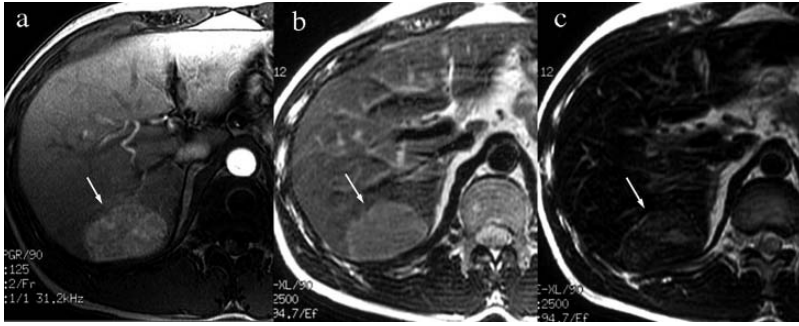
Focal nodular hyperplasia in a 34-year-old male. In the arterial phase of dynamic MR imaging, a well-enhanced tumor is noted in S7 (a, arrow). Pre-contrast T_2W -FSE reveals a high-intensity mass (b, arrow). On SPIO-enhanced T_2W -FSE, the tumor takes up SPIO and its signal intensity is decreased (c).
